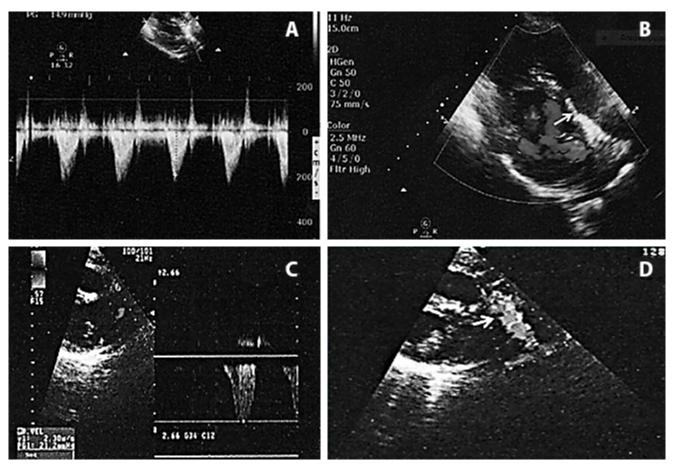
Panels A, B, C, D. Doppler and 2D echocardiogram, respectively, obtained from right parasternal view (RVOT) at 1-year follow-up demonstrating competent Venus (Panels A, B) P-valve and Melody® (Panels C, D) valves with a 15 and 21 mm Hg peak pulmonary pressure gradient.
